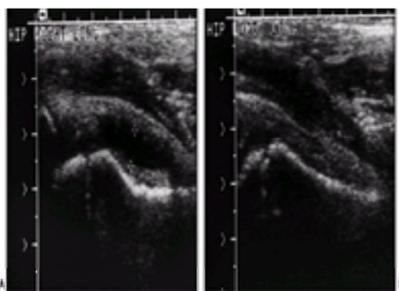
Longitudinal linear ultrasonographic view of the hips in a boy 5 years, 4 months of age, who had transient synovitis of the right hip. A: Ultrasound scan of the symptomatic right hip demonstrates a large joint effusion, as indicated between the cursor markings. B: Ultrasound scan of the asymptomatic left hip, for comparison, demonstrates no joint effusion.
